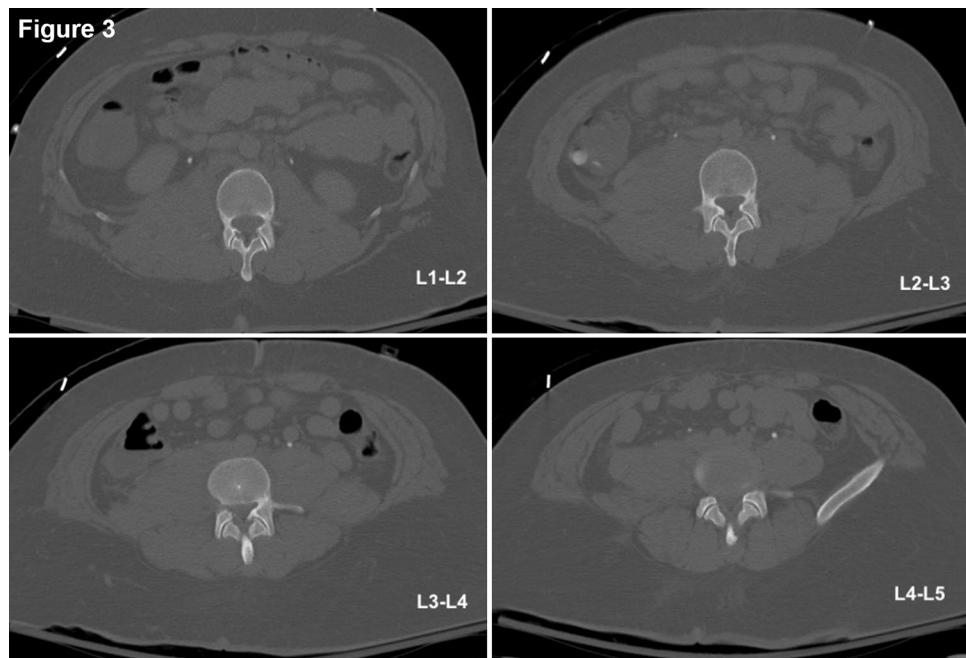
Computed tomography: the alignment of the pertinent lumbar facet joints look normal on axial images
